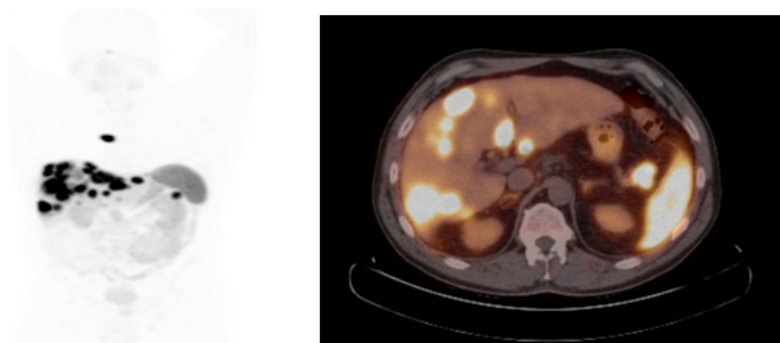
⁶⁴Cu DOTATATE PET/CT demonstrating somatostatin avid pancreatic and liver lesions.
